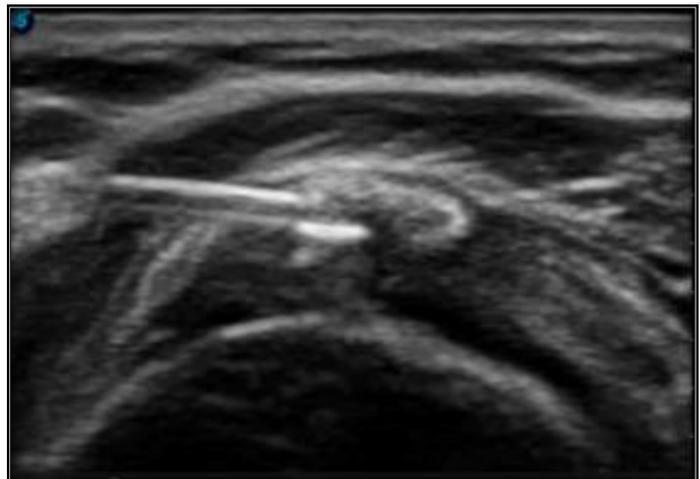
Sonographic Visualization of Intralesional Needle Placement
